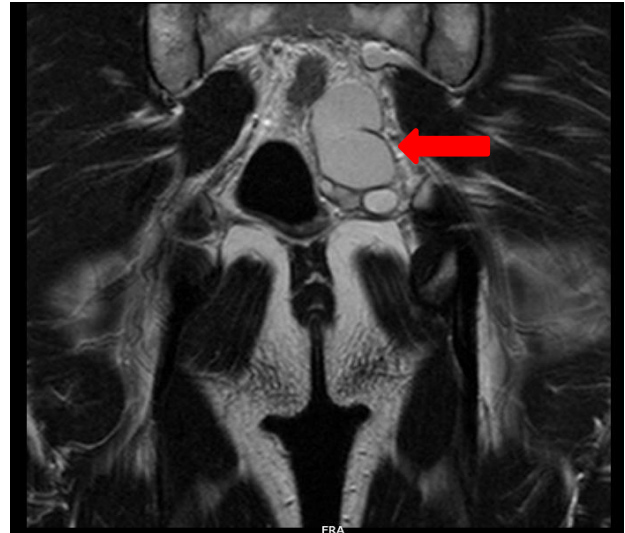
Coronal section of MRI abdomen and pelvis of the patient showing cystic and tortuous dilatation of the left seminal vesicle with mild to moderate hyperintensity on T2W imaging (marked in red arrow).
